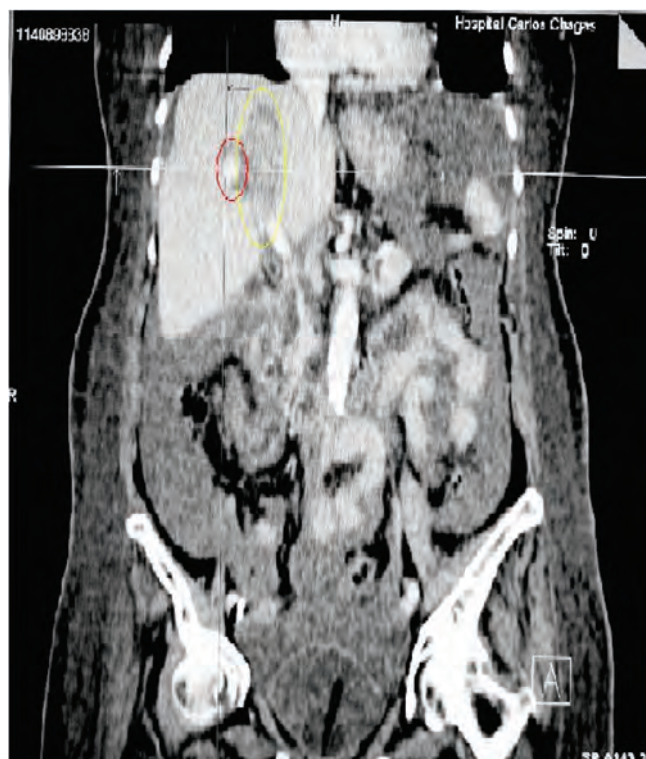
Abdominal CT scan with contrast showing right hepatic arterial malformation (smaller circle) and intra-parenchymal hematoma (larger circle).
